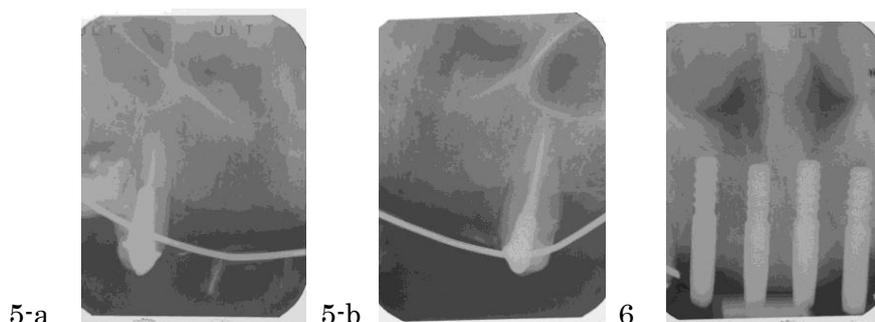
Dental radiograph taken right before excision of the pontic from the temporal bridge (03.11.2005).
